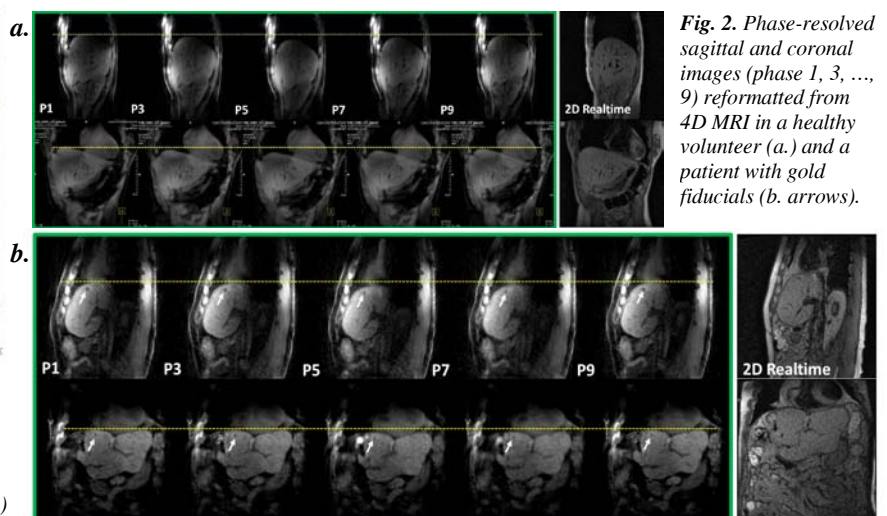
Phase-resolved sagittal and coronal images (phase 1, 3, ..., 9) reformatted from 4D MRI in a healthy volunteer (a.) and a patient with gold fiducials (b. arrows).
